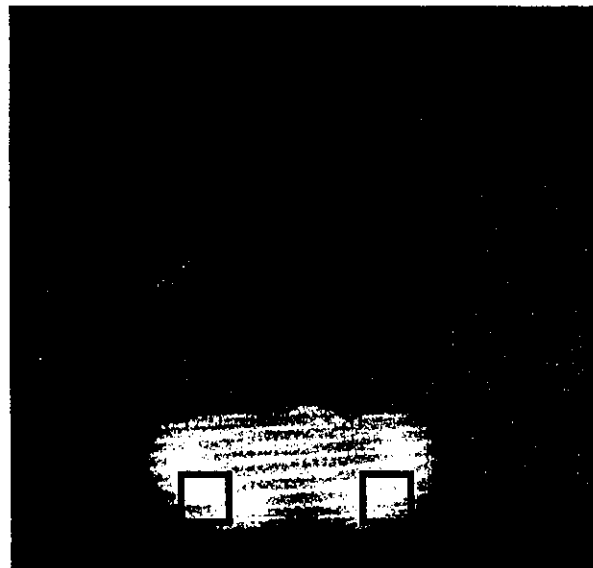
ROIs on a SPECT image of the cerebellum.
